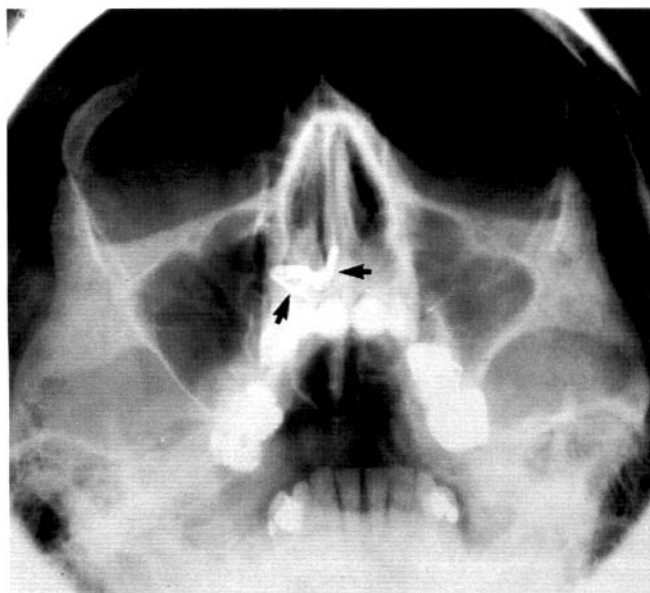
Radiograph of the head from the front (an *occipitomental* view) taken with the head tipped back, as described later in Chapter 12. This positioning lowers the dense bones of the base of the skull and raises the facial bones so avoiding superimposition of one on the other. A radiopaque (white) object (arrowed) can be seen apparently in the base of the right nasal cavity.
